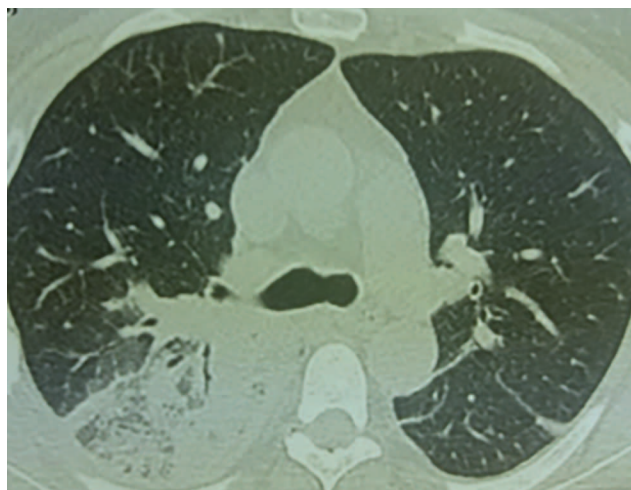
CT scan of the patient's lungs (description in text)
